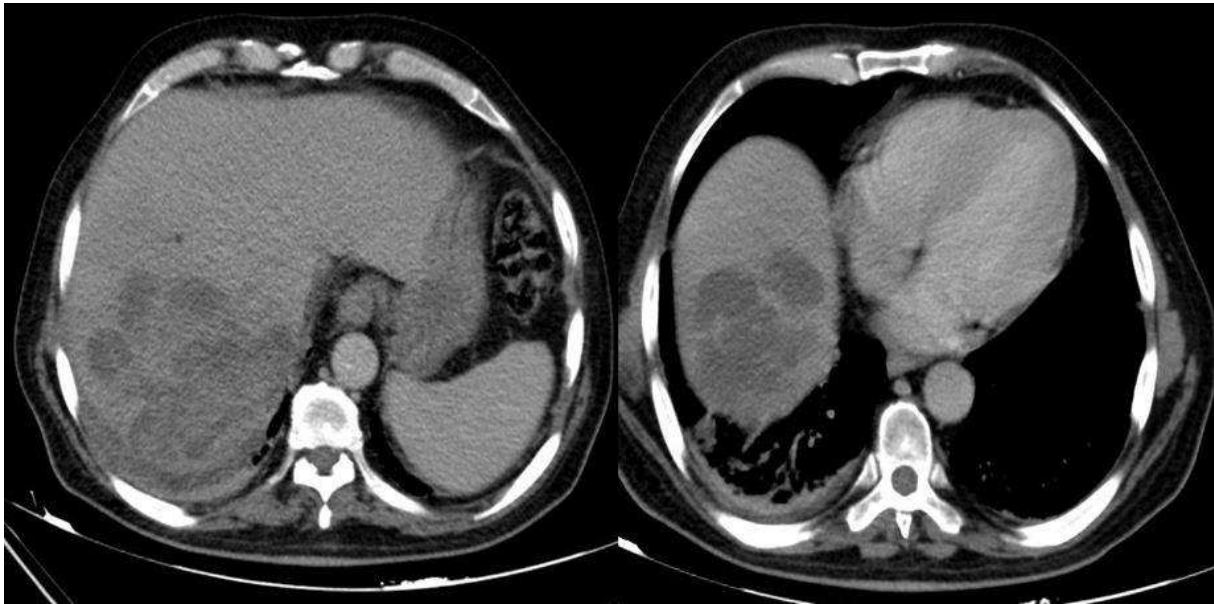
Abdomen CT image at control examination.
